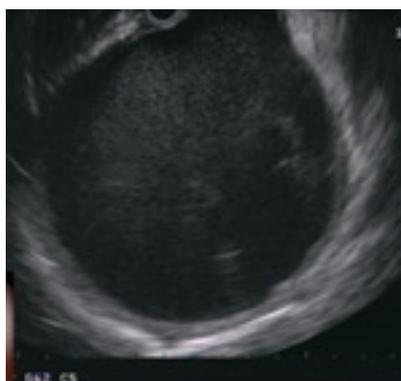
Endosonographic view of pancreatic pseudocyst.
